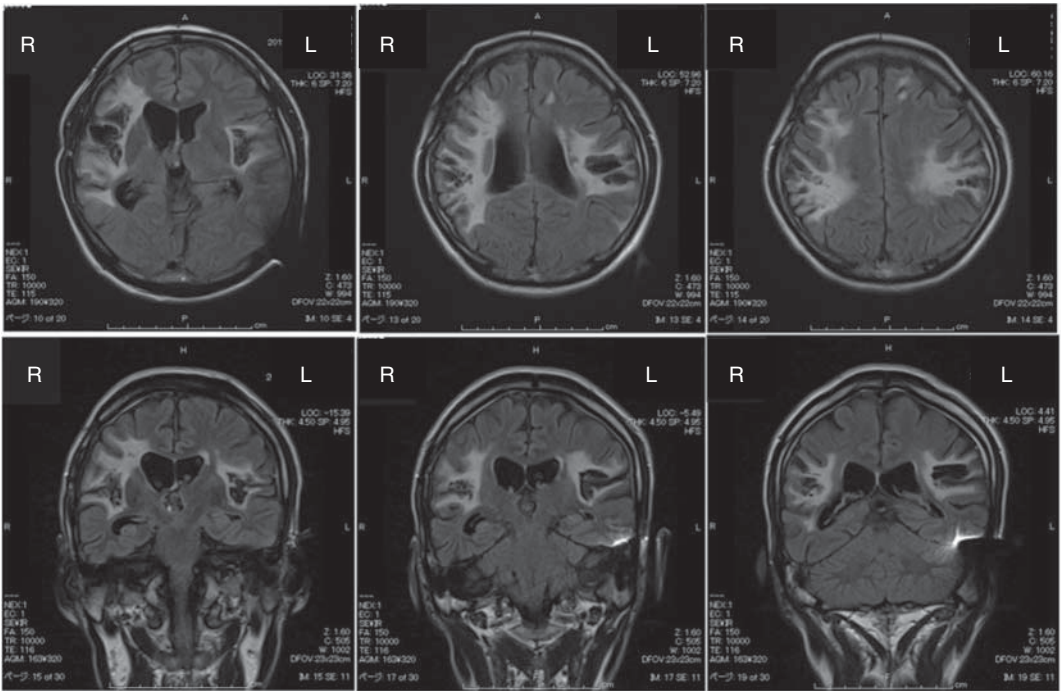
Brain imaging by MRI shows cerebrovascular lesions in bilateral regions. Flair images reveal lesions in bilateral auditory cortices, radiations, and postcentral gyri and the partial damage of the third frontal gyri.
